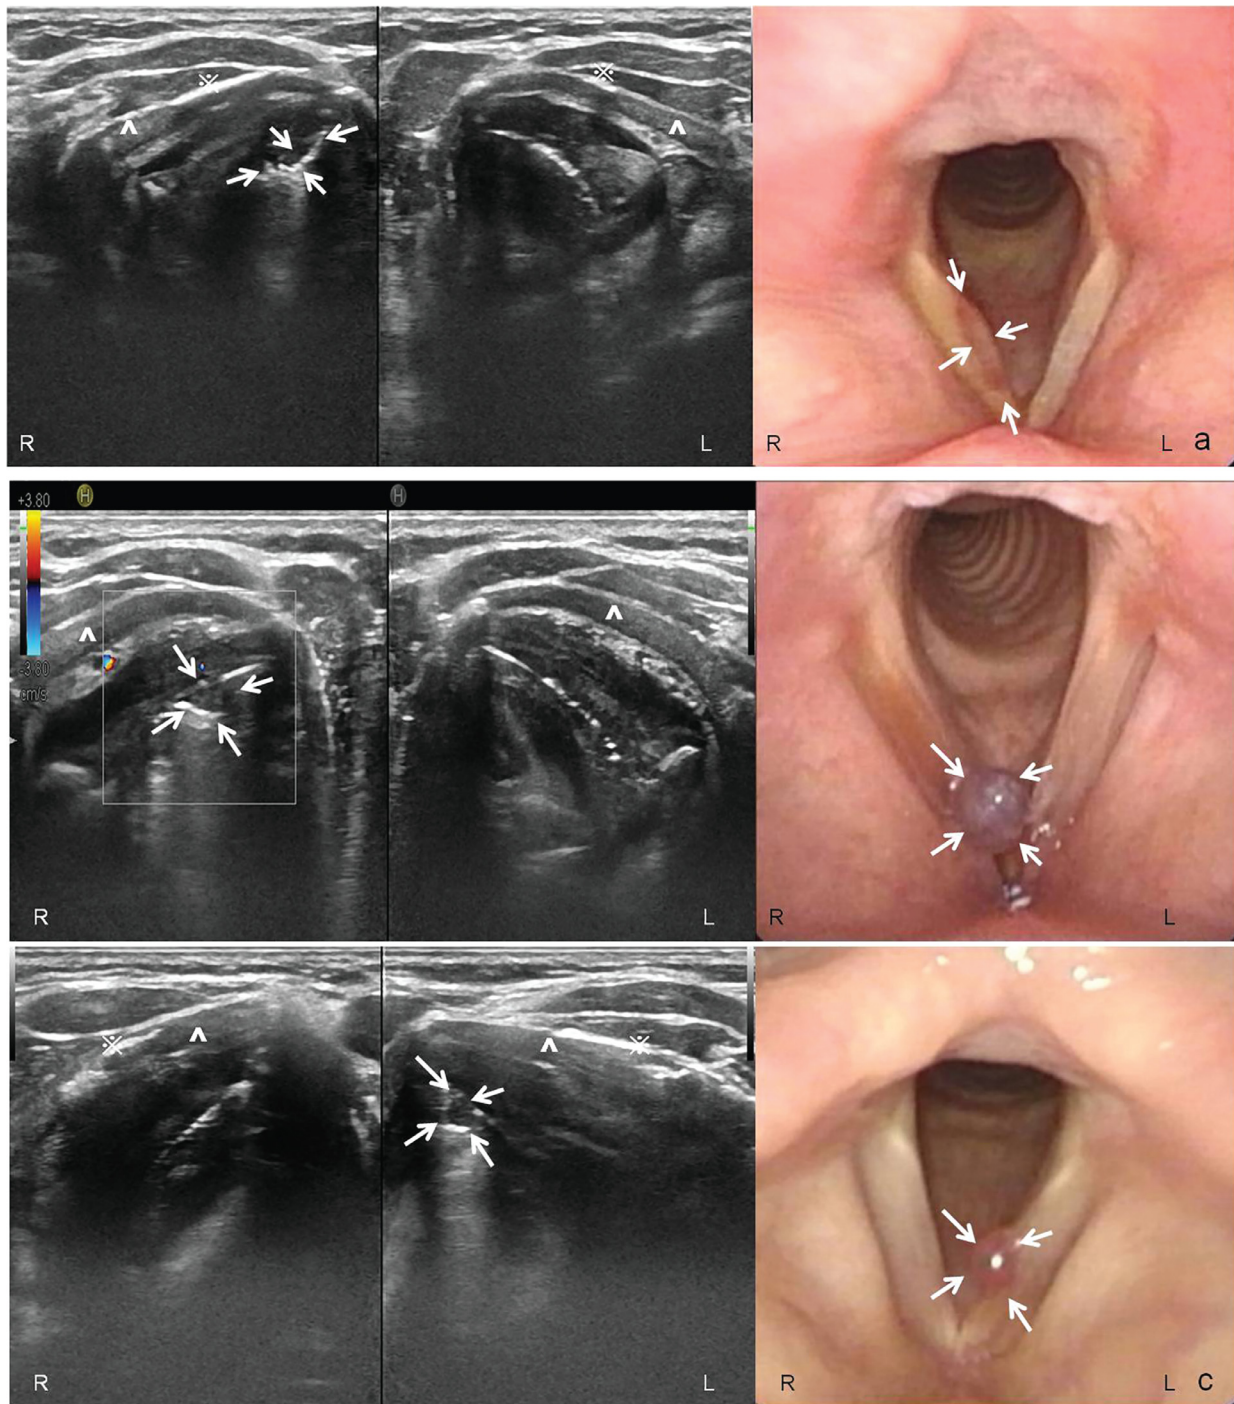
Ultrasonic manifestations of vocal polyps. (a) Non-circular polyps in the middle third of the right vocal fold. (b) Circular polyps in the first third of the right vocal fold. (c) Circular polyps in the first third of the left vocal fold. ^Thyroid cartilage. \*Calcification. ↑Polyp of vocal fold.
